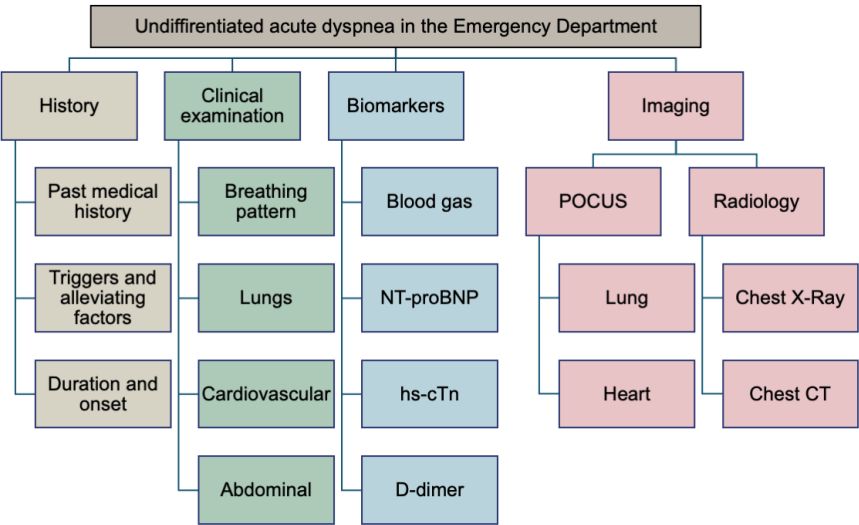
Approach to undifferentiated dyspnea in a non-critically ill patient in the ED. Adapted from Devos et al.[41]. Created in Microsoft PowerPoint. Abbreviations: NT-proBNP, N-terminal pro-B-type Natriuretic Peptide; hs-cTn, high-sensitivity cardiac Troponin; POCUS, point-of-care ultrasound; CT, Computed tomography.
